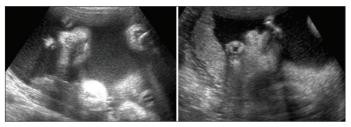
A 24-year-old G3 P2 was referred at 24 weeks of gestation. Ultrasound examination showed increased amount of the amniotic fluid and anencephaly
